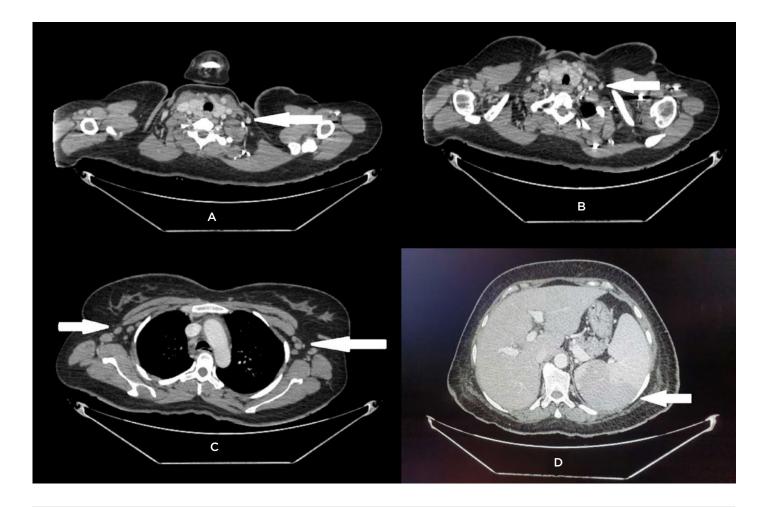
CT of A,B) neck; C) chest; and D) abdomen, showing bilateral cervical and axillary lymphadenopathy and splenomegaly.
